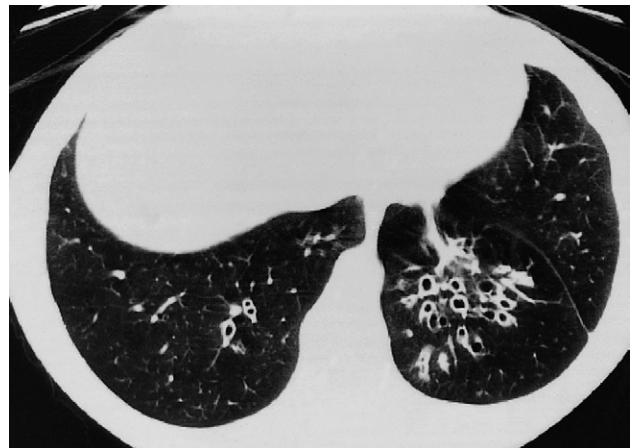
Bronchiectasis. HRCT showing thick-walled, dilated bronchi crowded together in the left lower lobe. The normal appearance is seen in the right lower lobe.
